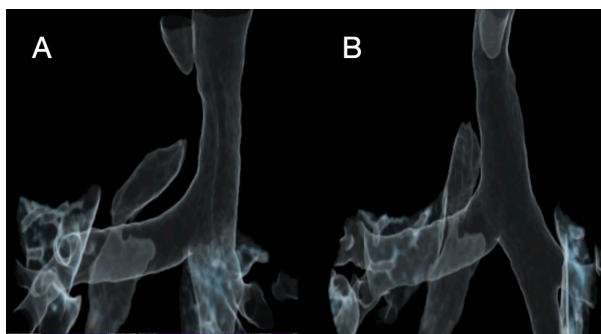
3-D reconstructions of the CT scan of the trachea showing its indicated clamp-like narrowing due to the course of the aorta.
